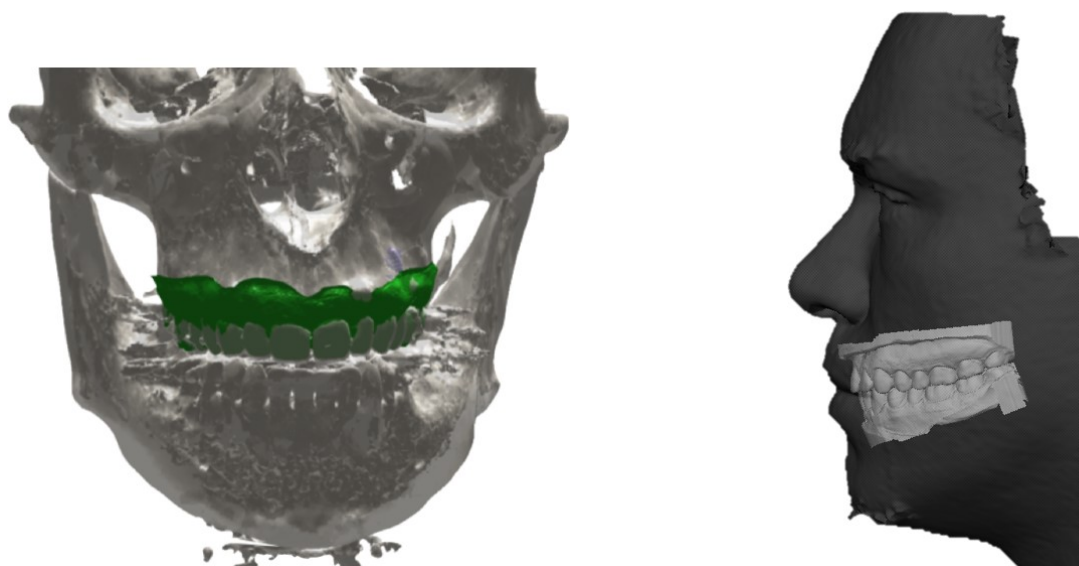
Example of virtual patient models, on the right is depicted a model that integrates CBCT bone rendering, the 3D digital model of patient dental arch and the CAD model of the dental implant. On the left is depicted an virtual model composed by the stereophotogrammetric facial surface and the digital dental casts of the patient
